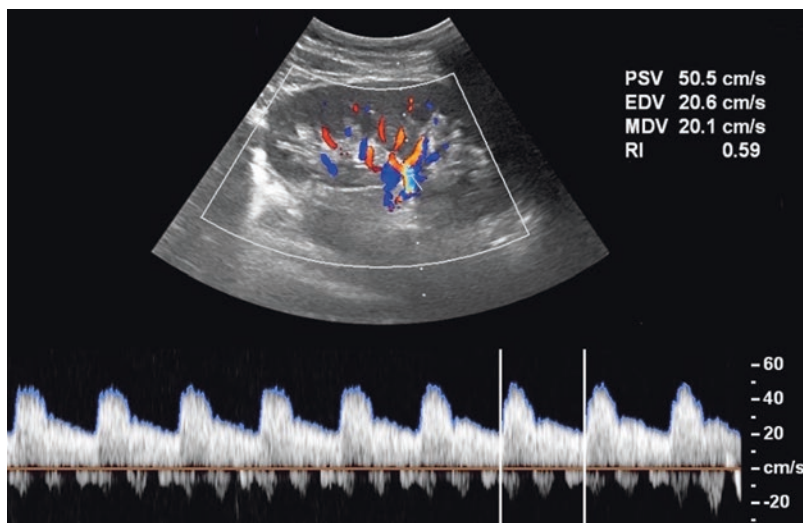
Color and spectral wave Doppler of the main renal artery at the hilum (RI 0.59)
